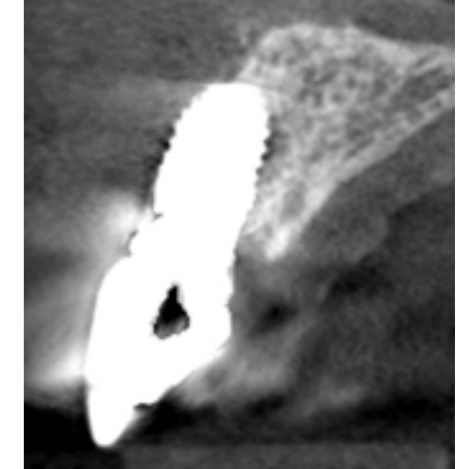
Initial CBCT. The wide diameter (5.5mm) and the wrong positioning of the implant in the upper central incisor area contributed to the loss of the buccal hard and soft tissues.
